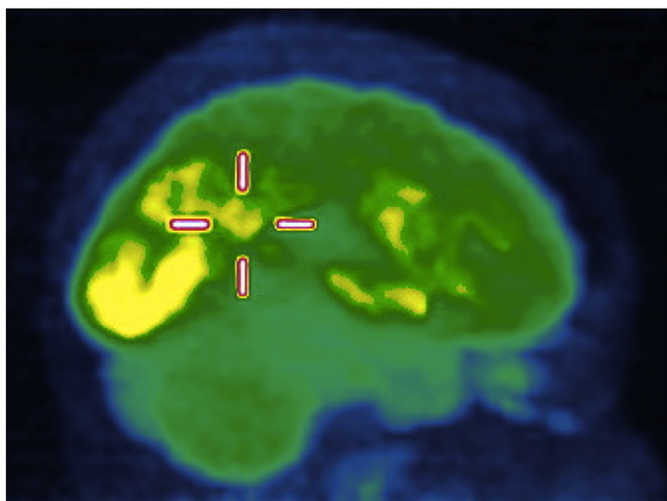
FDG-PET study showing hypometabolism in the right temporo-parietal junction of a patient with feeling-of-a-presence.
